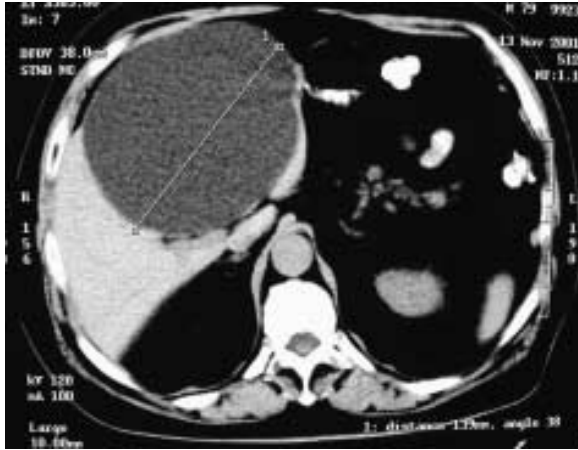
CT scan showing a solitary cyst in the right lobe of the liver.
